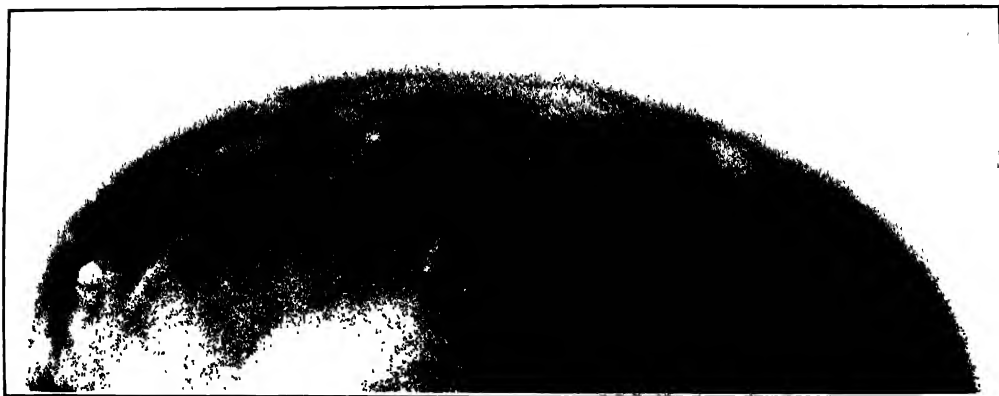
Exostoses frontalis interna. This condition, described by Dr. Sherwood Moore, consists of exostoses on the inner table of the skull. In this roentgenogram the exostoses are seen at the left edge of the figure on the inner table in the frontal area. This is the skull plate of the patient shown in Fig 310 (Moore—*Am. J. Roentgenol.*)
